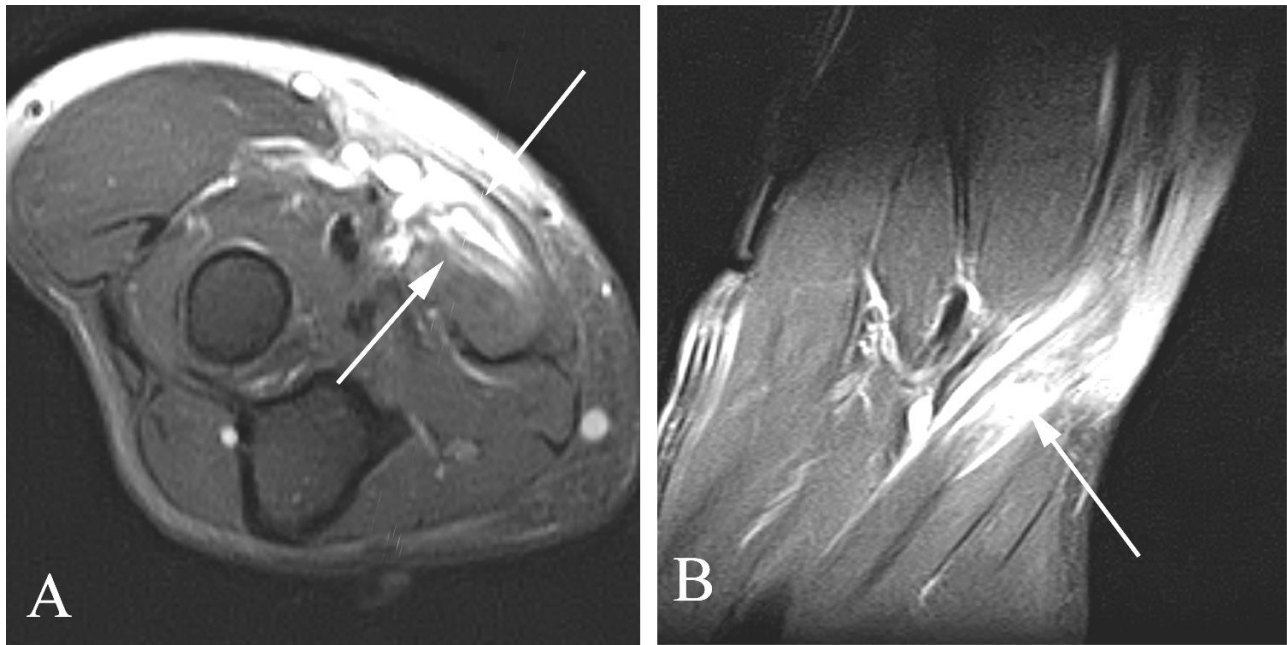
Pronator teres muscle tear in a 58 year old woman with pain following a golfing injury. A. Axial T2 weighted MR image demonstrates abnormal signal (arrow) in the pronator teres muscle. B. Coronal T2 weighted MR image shows a small focal hematoma (arrow) of the pronator teres muscle.
